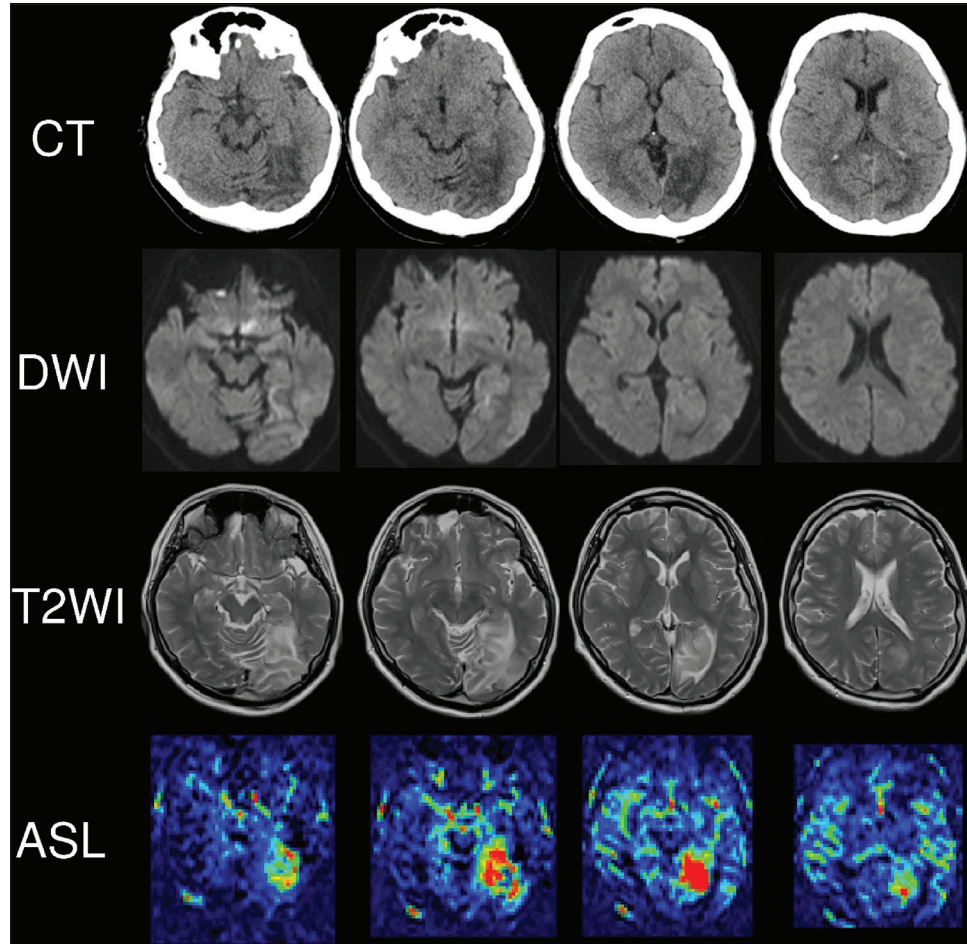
Neuroimaging on day 1. Head computed tomography revealed a low-density area in the left occipital lobe. The diffusion-weighted image and T2-weighted image showed high-intensity area, and arterial spin labeling image described cerebral blood flow increase in the same region.
